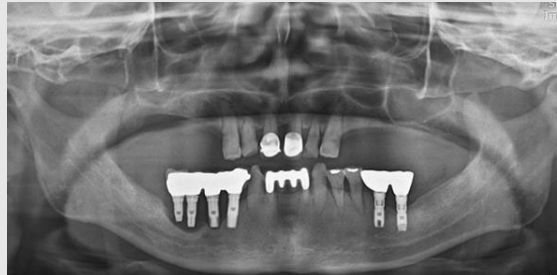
Radiographic evaluation of failing implants placed at the site of right posterior mandible.
